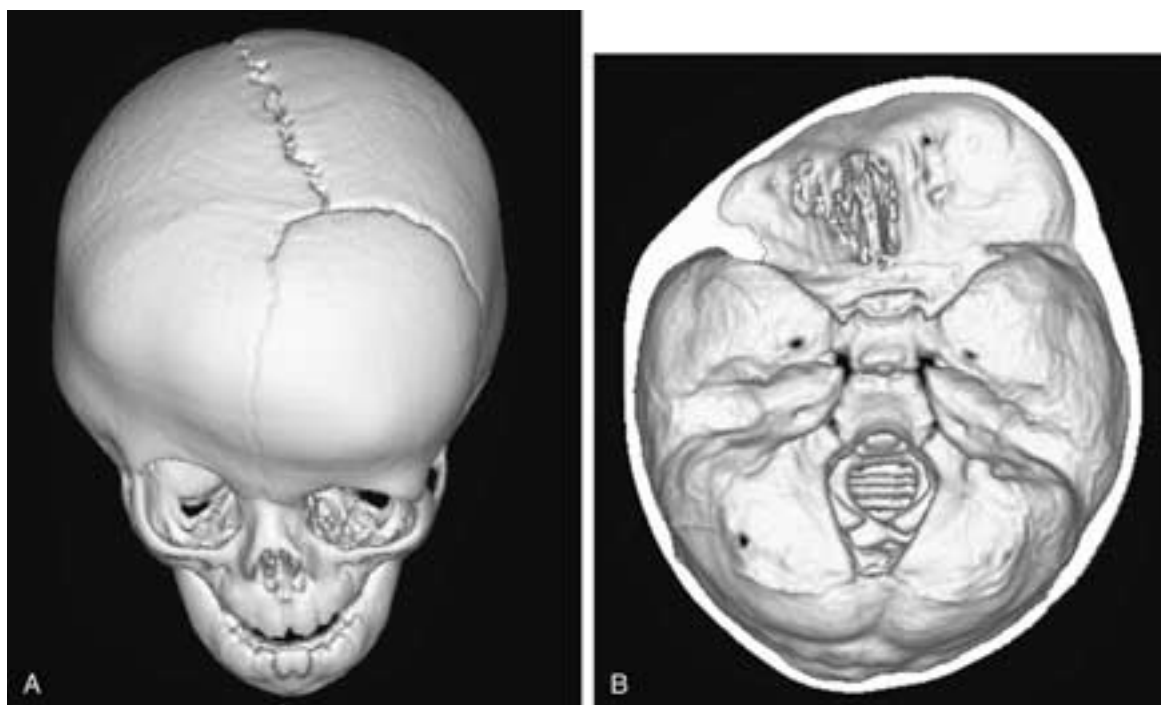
Nonsyndromal unilateral right coronal synostosis in a 7-month-old girl. A and B, Three-dimensional CT of the cranial surface (A) and a view of the skull base from within (B). The right coronal suture and anterior fontanelle are closed. The sagittal and left coronal sutures are patent. The metopic suture is faintly visualized. Asymmetric closure of the right coronal suture restricts growth of the ipsilateral anterior fossa and orbit, causing plagiocephaly, harlequin right eye, short right anterior fossa, high position of the right sphenoid wing-pterion, compensatory bossing of the left frontal contour, and inferior displacement of the left orbit.
